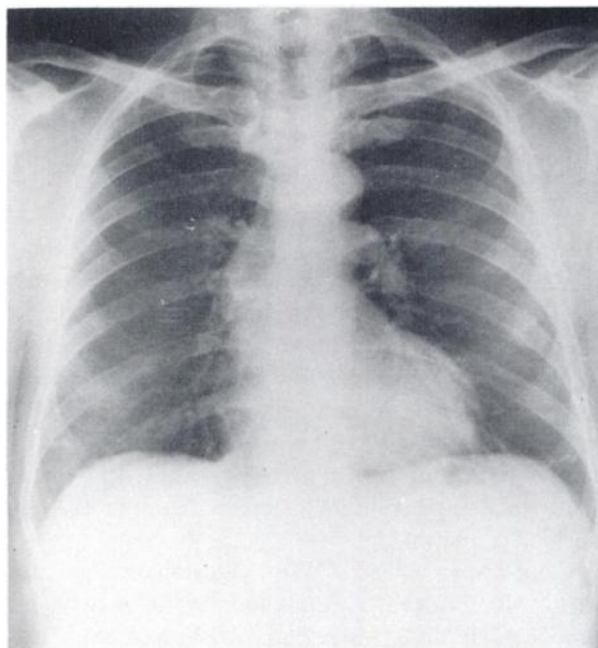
X-ray film of chest taken 10 days after admission. There is no radiologic evidence of calcification of lungs.
